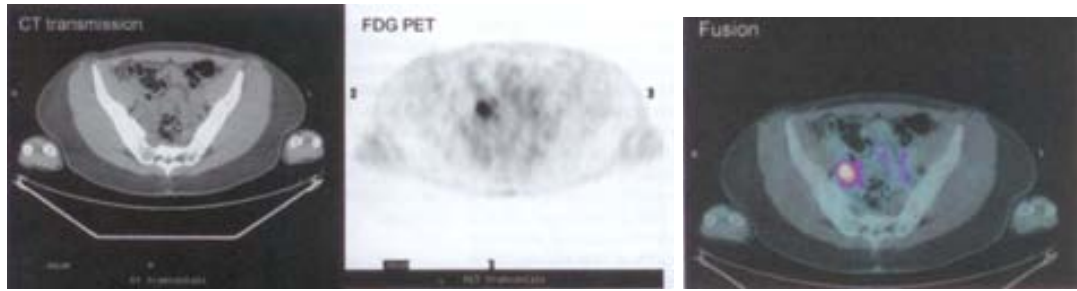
The transaxial image through the pelvis of a 31-year-old woman. Left: pelvic CT scan does not demonstrate any pathology. Center: PET scan clearly shows the place of FDG uptake. Right: the fusion image. The figures are taken from [90].
